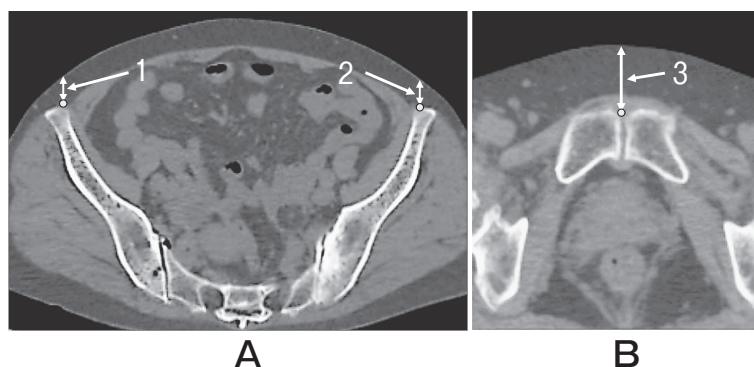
CT images adjusted to the functional pelvic plane. A, Measurement of ASIS-thicknesses; B, Measurement of PS-thicknesses. 1, ASIS-thickness on right side; 2, ASIS-thickness on left side; 3, PS-thickness. ASIS, anterior-superior iliac spine; PS, pubic symphysis; CT, computed tomography.
